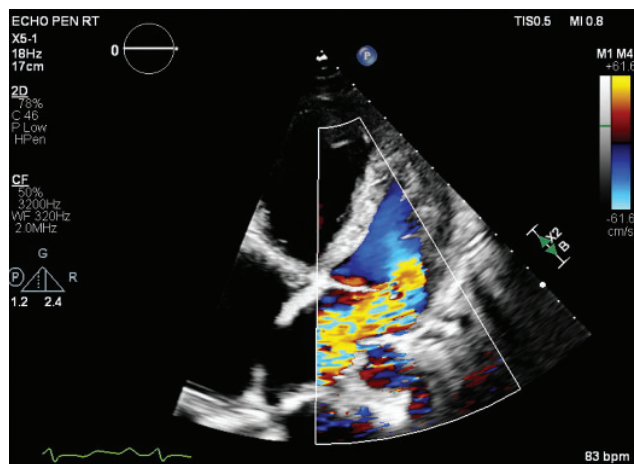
Transthoracic echocardiography apical 4-chamber color Doppler view showing severe eccentric, anteriorly directed mitral regurgitation (proximal isovelocity surface area radius 1.0 cm, aliasing velocity 61.6 cm/second, mitral regurgitation maximum velocity 411 cm/second, mitral valve velocity time integral 81.6 cm, effective regurgitant orifice area 0.94 cm², regurgitation volume 77 mL).
